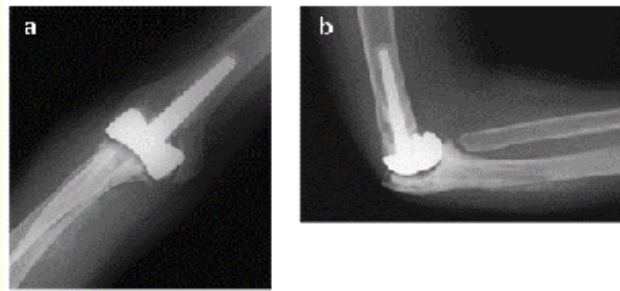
Plain radiographs after second revision TEA.
